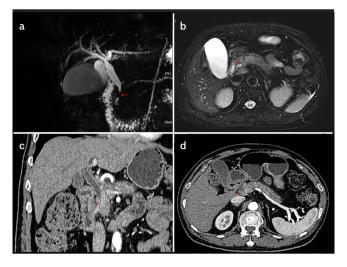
a-d. Abdominal MRI+MRCP and enhanced abdominal CT: a) MRCP shows localized stenosis (red arrow) in the lower segment of the common bile duct and slight dilatation in the upper segment. b) T2-weighted imaging (T2 WI) staging shows localized thickening (red arrow) of the bile duct wall in the pancreatic segment and a slightly enlarged pancreatic head with an uneven signal; the possibility of a tumor was not excluded. c) CT with coronal reconstruction with thickening of the common bile duct wall in the lower segment (red arrow). d) Inflammatory changes in the pancreas, with enlarged lymph nodes behind the common bile duct (red arrow).
